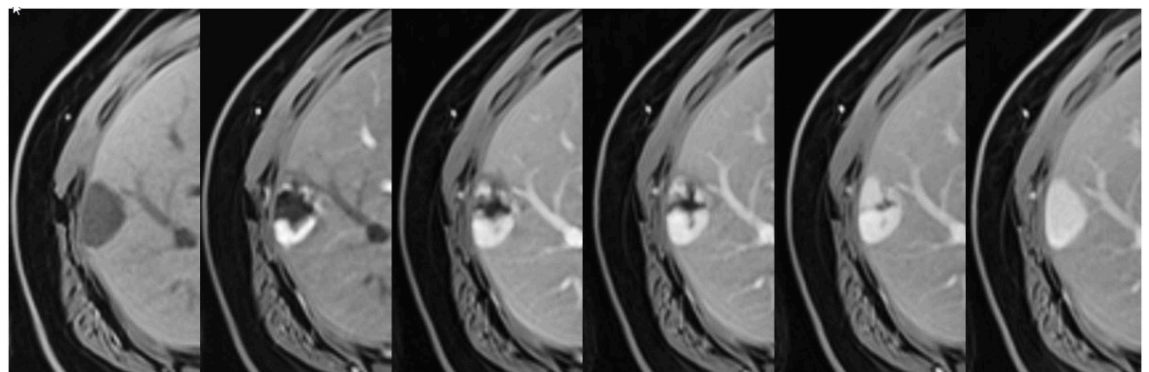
Haemangioma on MRI. Subcapsular haemangioma with hypointense signal on the unenhanced T1w image (left) and after contrast administration peripheral nodular enhancement with filling in over time and hyperintense signal matching the blood pool on delayed phase (right).
